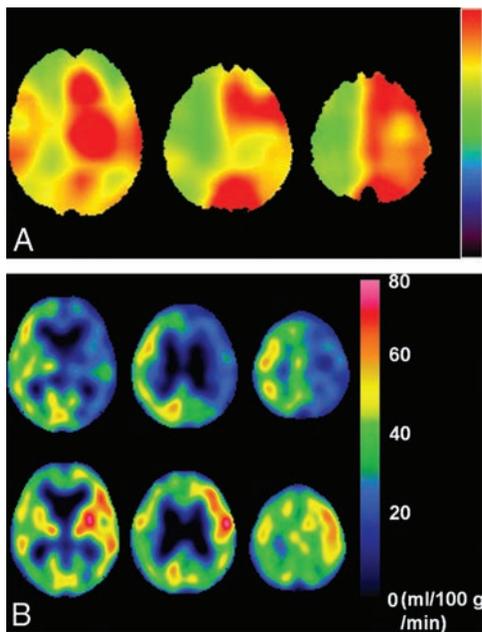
A 77-year-old man with symptomatic left internal carotid artery stenosis (85%) who developed cerebral hyperperfusion syndrome with right-sided hemiparesis and aphasia with onset 5 days after the operation. *A*, Preoperative QSM-OEF images show elevation of the values in the left cerebral cortex compared with those in the right cerebral cortex. *B*, Brain perfusion single-photon emission CT images before the operation show hypoperfusion in the left cerebral hemisphere (*upper row*) where hyperperfusion developed immediately after the operation (*lower row*).
